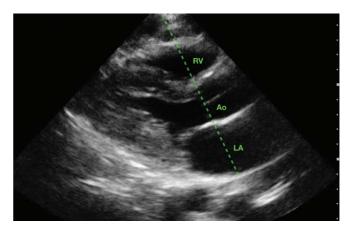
Rapid assessment of chamber enlargement on parasternal long axis using the "Rule of 3s." Note that each chamber (right ventricle, aorta, left atria) are roughly the same diameter through the dashed line, with about 6 to 7 dashes per chamber.
